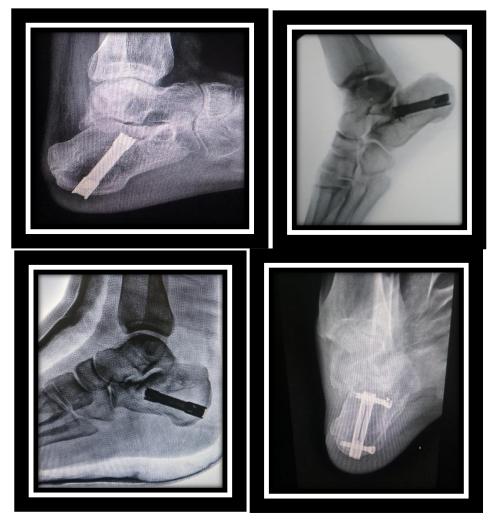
Postoperative radiography-osteosynthesis by nail calcanail
